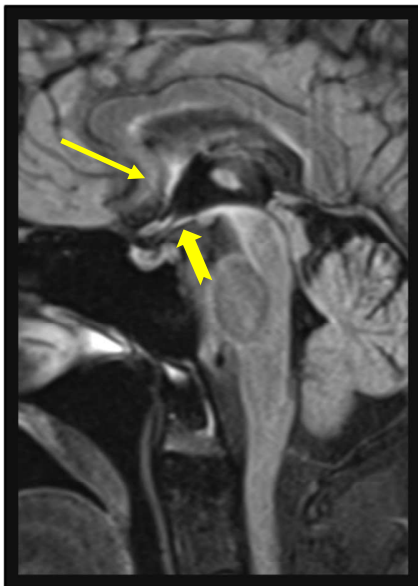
Sagittal FLAIR shows hyperintensities of the midbrain, lamina terminalis (straight arrow) and tuber cinereum (notched arrow).
